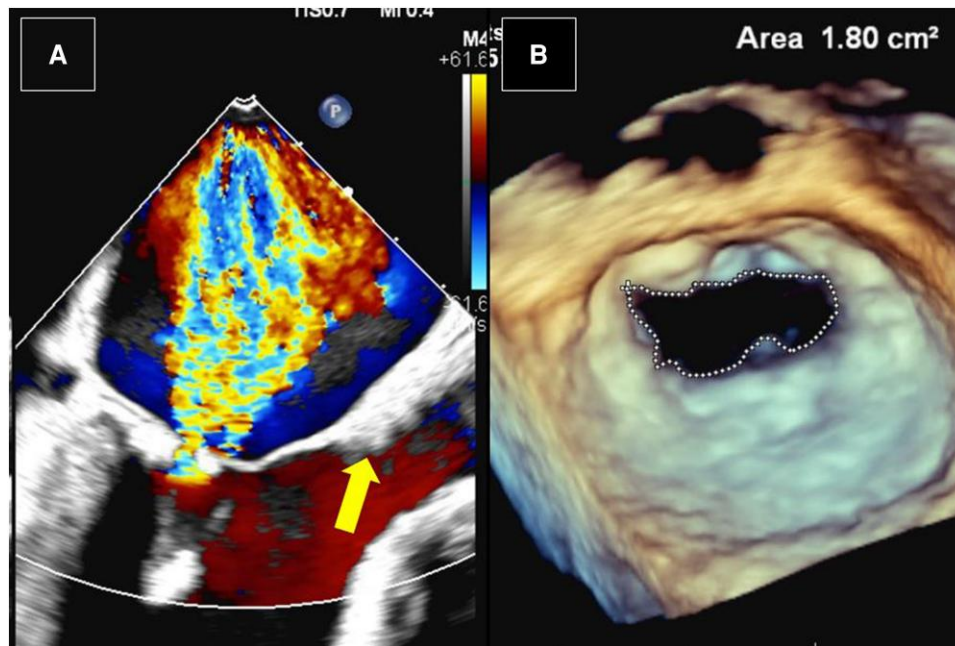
(A) Transoesophageal echocardiography view at 120° showing severe mitral regurgitation along with transcatheter aortic valve implant *in situ* (yellow arrow). (B) A Three-dimensional zoom image of the mitral valve (en face view) showing restricted mitral opening.
